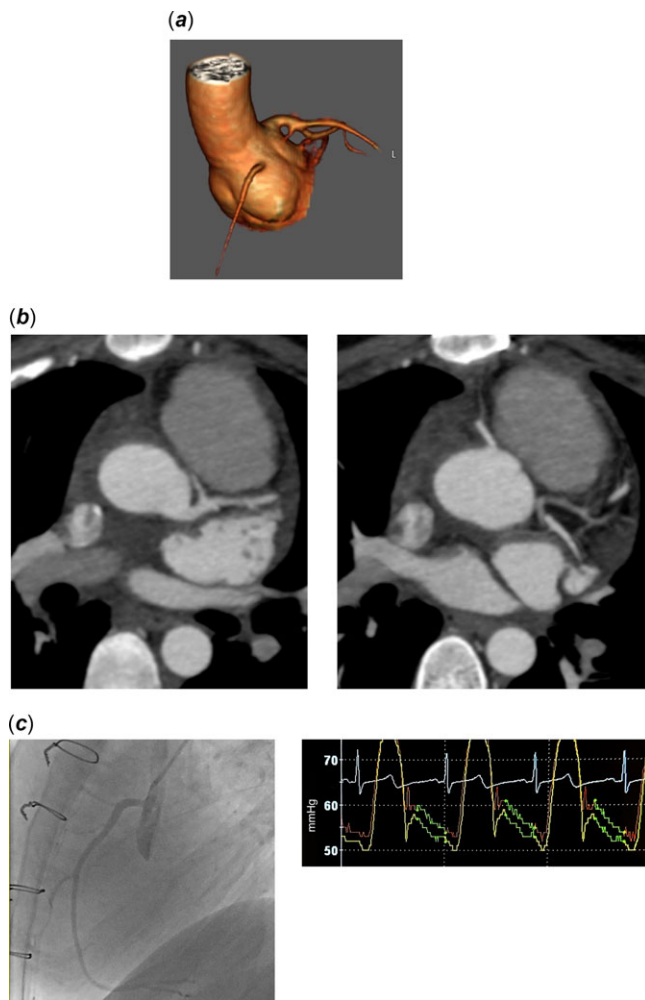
Preoperative imaging. (a) Three-dimensional reconstructions from CTA of preoperative coronary anatomy, viewed from a rotated coronal plane (left) and axial plane (right), demonstrating the single coronary artery originating from the left coronary sinus and trifurcating into an RCA, LAD, and left circumflex. (b) Representative oblique (left) and axial (right) cuts from preoperative CTA demonstrate the compressed interarterial course of the RCA. (c) Anatomy was confirmed on coronary angiography during cardiac catheterisation and significant RCA compression was noted based on invasive haemodynamic measures. Ao = aorta; CTA = computed tomography with coronary angiography; LAD = left anterior descending artery; LCx = left circumflex coronary artery; RCA = right coronary artery.
